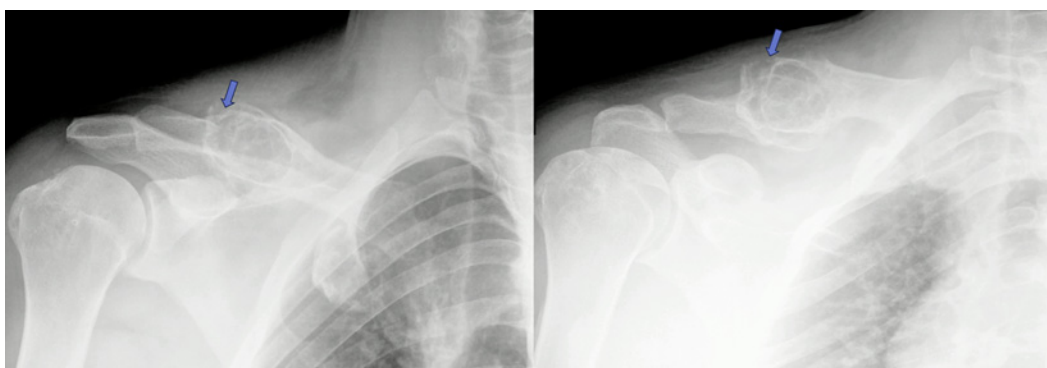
Plain radiographs showing an incomplete pathological diaphyseal fracture within an expanded osteolytic lesion of the middle third of the right clavicle (blue arrow pointing to the fracture).
